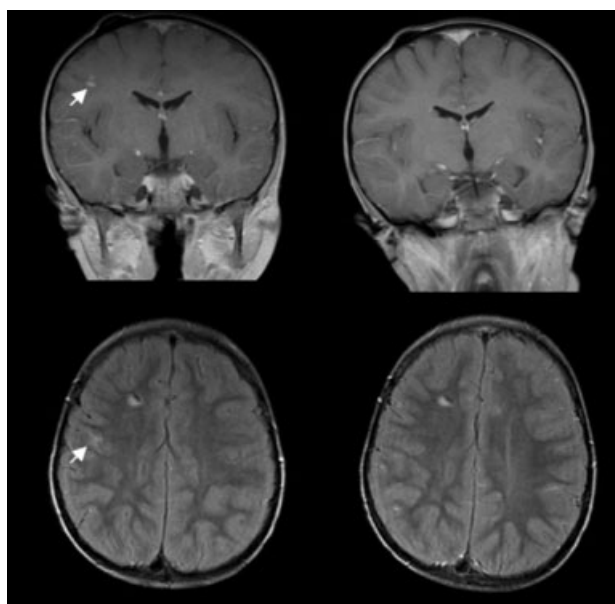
Magnetic resonance imaging (MRI) of a complete response of recurrent medulloblastoma to the oxaliplatin and etoposide regimen. (*Top*) Coronal postcontrast T1-weighted MRI scans show a (left, arrow) focal metastasis deep within a sulcus in the right frontal lobe that (right) resolves after therapy. (*Bottom*) Postcontrast fluid attenuation inversion recovery (FLAIR) MRI scans show the same focal metastasis (left) before and (right) after therapy.
